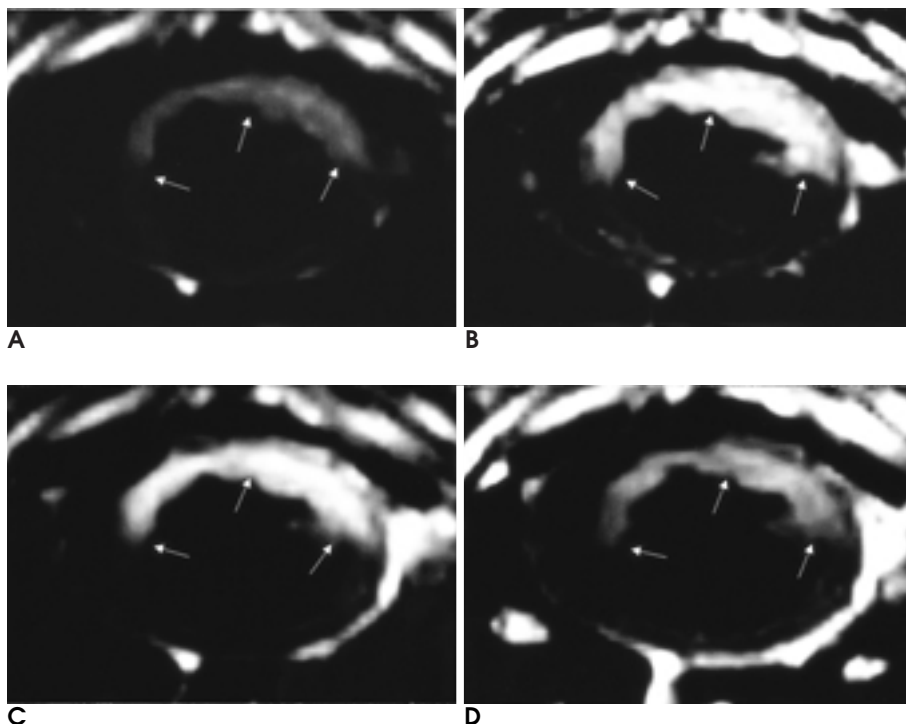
Example of MR images of time-course of enhancement.
